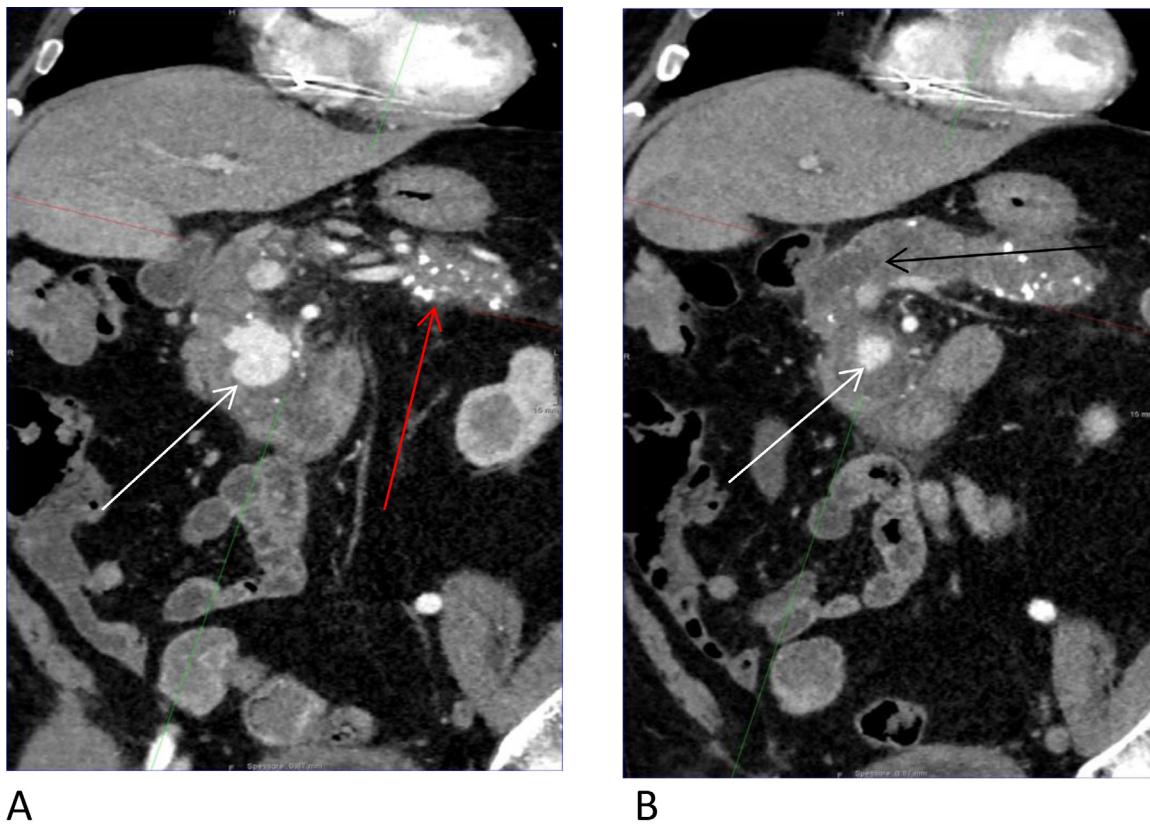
Coronal contrast-enhanced CT image showing an enlarged pancreas with multiple calcifications (red arrow) (A) and a marked dilation of the pancreatic duct (black arrow) (B). A pseudoaneurysm at the level of the head of the pancreas is evident (white arrows) (A and B).
